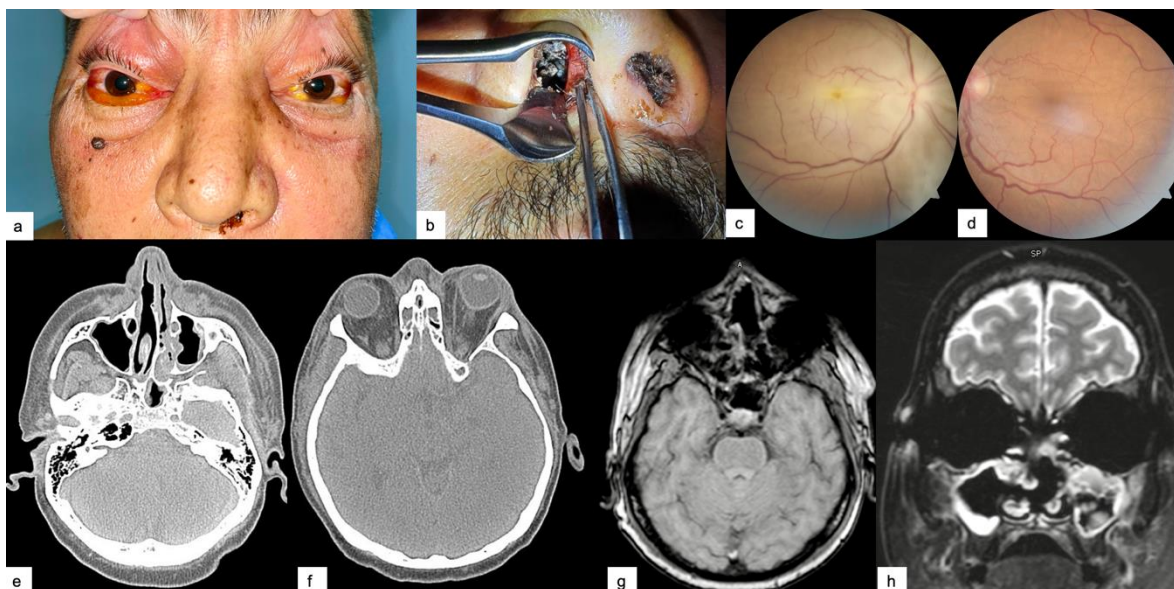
(a) Ophthalmoplegia, blepharoptosis, eyelid edema, chemosis and fixed and dilated pupils. (b) Necrotic tissue in the right nasal fossa. (c) CRAO on right eye (d) left eye with no alterations (e) paranasal sinus CT revealed maxillary sinusitis and (f) orbita CT showed bilateral orbital cellulitis. (g,h) Orbita MRI bilateral globe exenteration.
